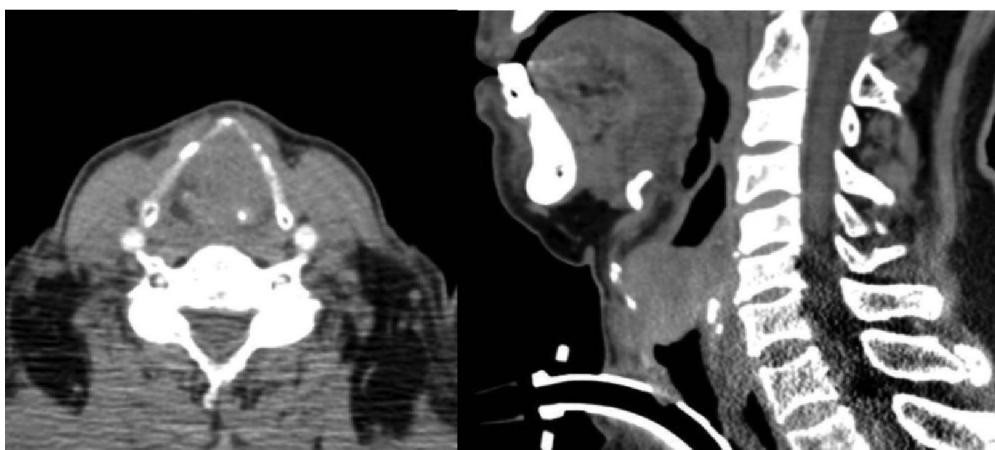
Male 83-year-old patient. Computed tomography in axial and sagittal plane showed the large tumor extended in all 3 regions of the larynx. Pathology showed squamous cell carcinoma
